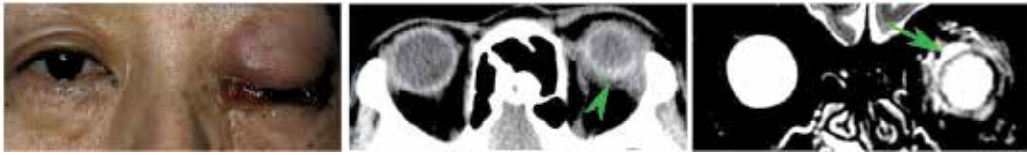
Orbital cellulitis. A 60-year-old woman with orbital cellulitis had right upper lid swelling, chemosis, and ptosis at active phase. CT image shows fuzzy diffuse pattern in the orbit (arrowhead) and a lack of mass lesions. Fat-suppressed T2-weighted MR image shows high intensity signals that extend diffusely to the orbit (arrow). Compare the image with those of orbital myositis (Figure 1 to 7).
